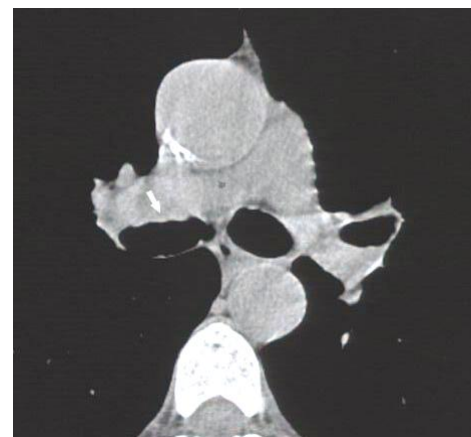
Second case's axial chest CT shows marked enlargement of main bronchi and corrugated appearance of bronchial wall (arrow).
